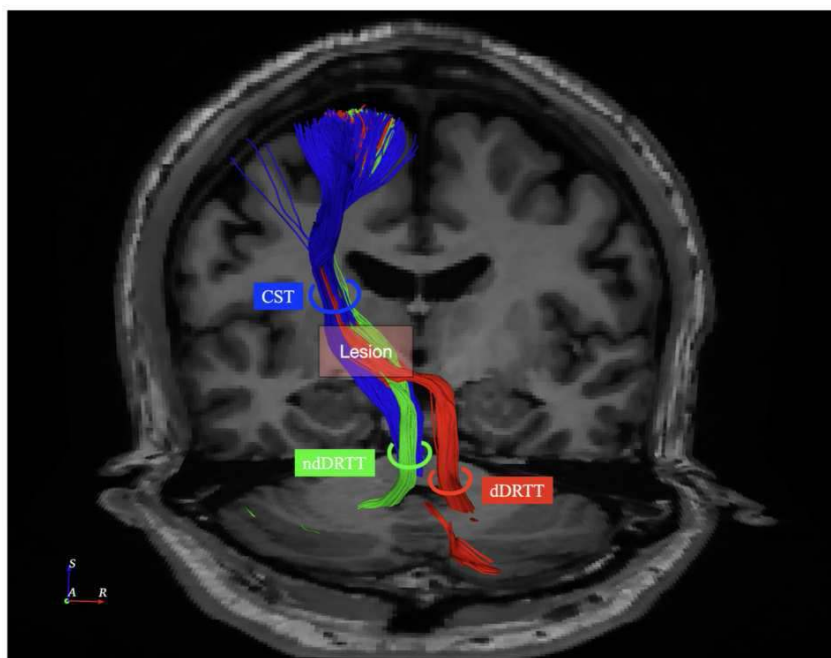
Demonstration of CST, dDRTT and ndDRTT. The indice was measure over the lesion site where focus ultrasound produce lesion.
